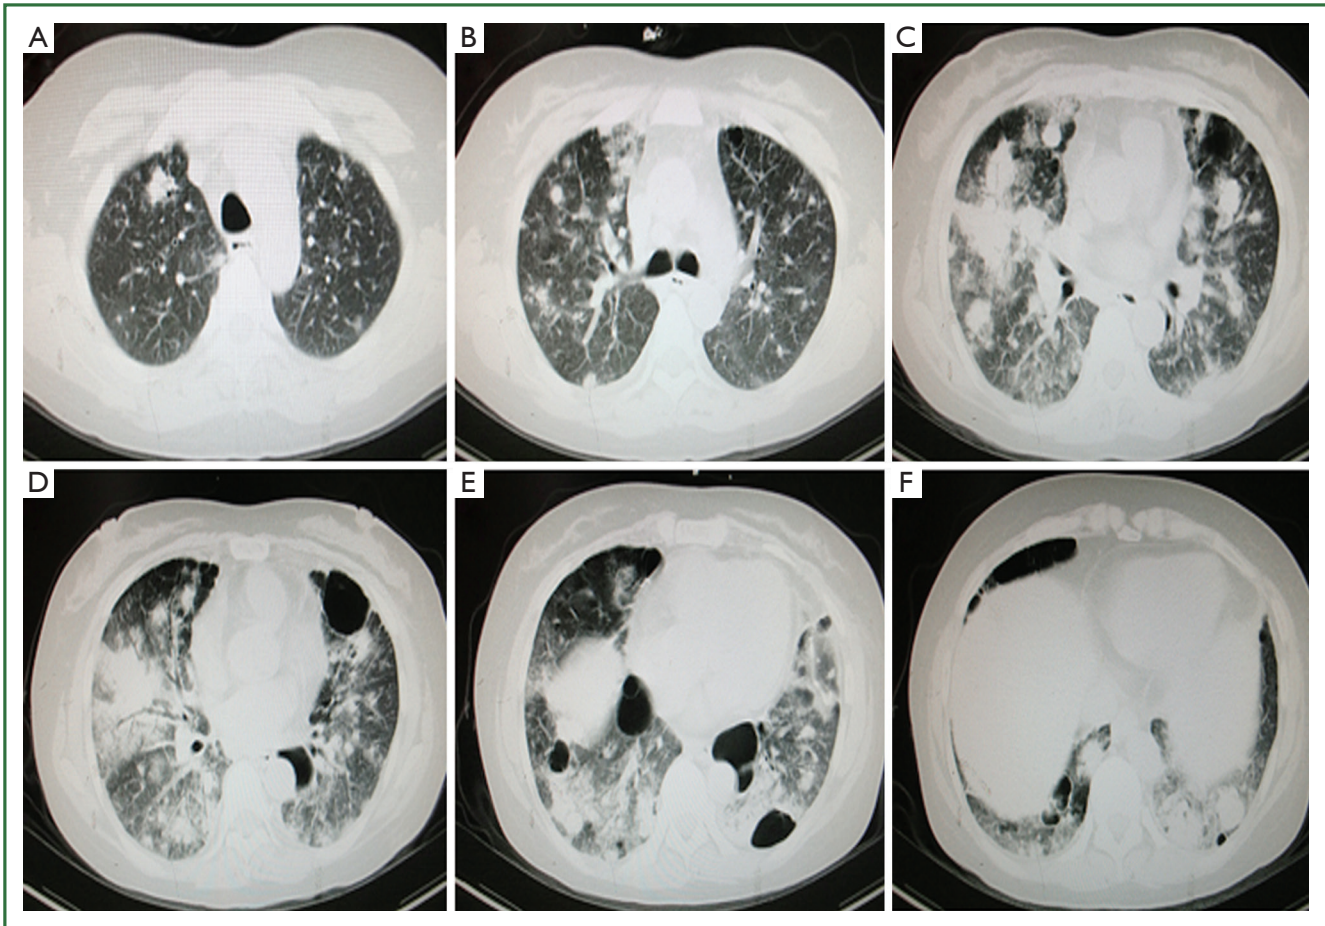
CT scan of the chest showing the infiltrative lesions with multiple cysts in both lungs.
